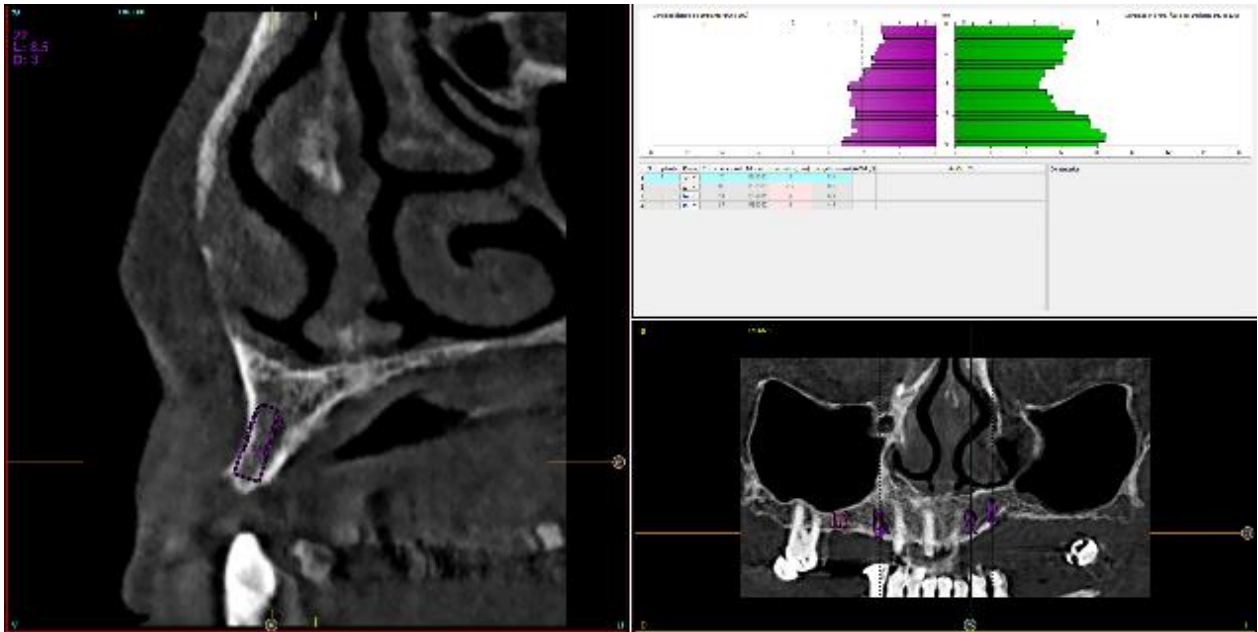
Initial radiographic image of the patient showing severe mixed atrophy in the second quadrant
